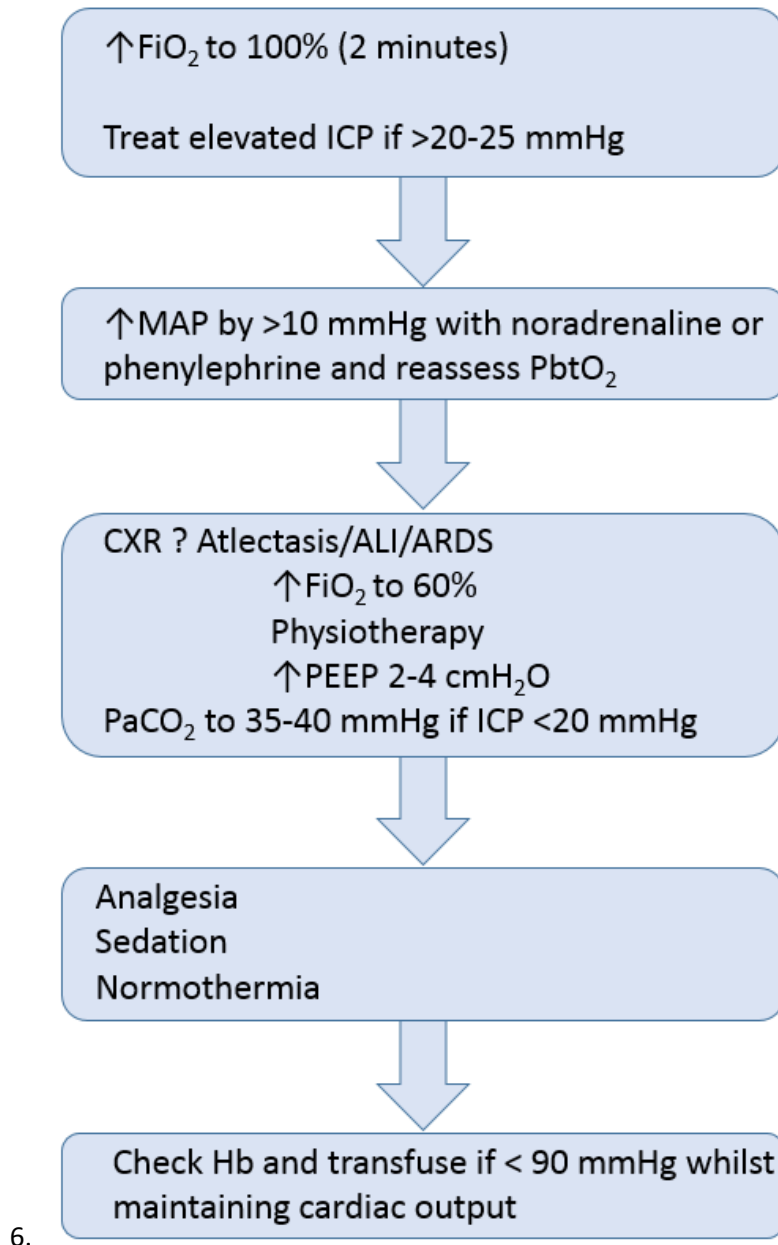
Proposed Management of Low Partial Brain Oxygen Tension. FiO_2 , fraction of inspired oxygen; ICP, intracranial pressure; MAP, mean arterial pressure; P_{btO_2} , partial brain oxygen tension; CXR, chest x-ray; ALI, acute lung injury; ARDS, acute respiratory (104).
